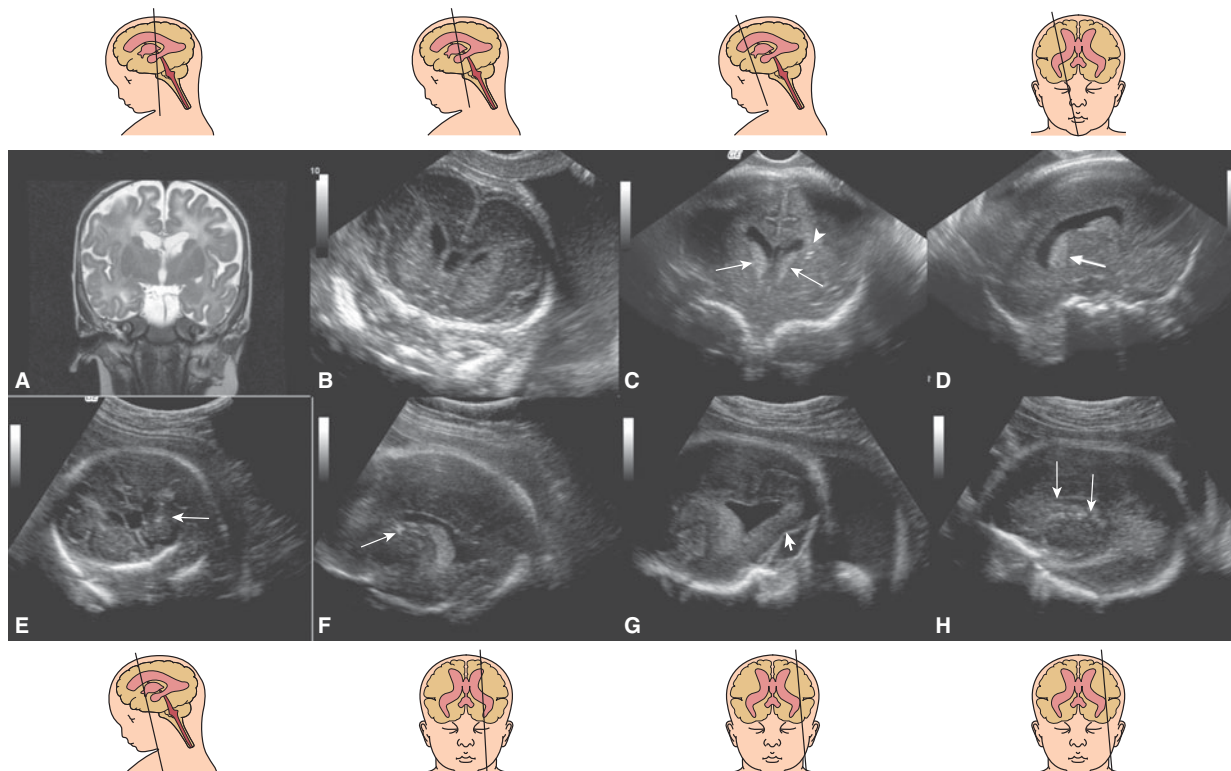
Siblings with autosomal recessive multiple mitochondrial DNA (mtDNA) deletions. (A) T2-weighted brain MRI of the proband at 3 years of age shows diffuse white matter involvement and caudate nuclei cystic formations. (B) Coronal transvaginal sonography (TVS) of the first fetus at 24 weeks is normal. (C). (D) Abnormal US findings diagnosed at 33 weeks' gestation in the same fetus as in B showing hyperechoic caudate nuclei (arrows) and small calcification foci (arrowhead). Coronal (E) and sagittal (F–H) images of the second fetus at 34 weeks' gestation show caudothalamic calcifications (arrows) and abnormal occipital white matter with abnormal sulcation (arrowhead).
